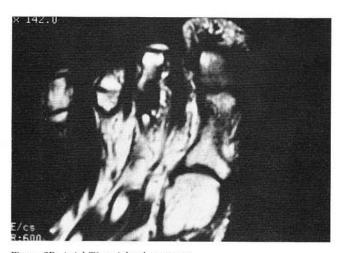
Axial T1-weighted sequence.
